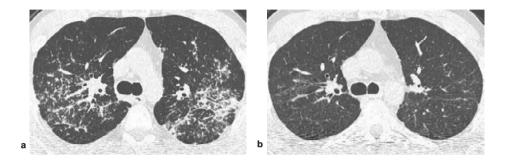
High-resolution computed tomography (HRCT) studies from a 36-year-old man with a history of 5 years of biopsy-proven sarcoidosis. Because of respiratory functional impairment, he had been previously treated with prednisone, starting at 40 mg daily. This was tapered off because of side-effects to 20 mg daily. No improvement was achieved, so treatment with methotrexate (MTX) was started. a. HRCT before treatment with MTX, showing multiple intraparenchymal nodules, focal pleural thickening, septal and nonseptal lines, and thickening or irregularity of the bronchovascular bundle. De h. HRCT after 6 months of treatment with 12.5 mg MTX weekly and 5 mg folic acid once a week orally, together with 10 mg prednisone daily, showing substantial improvement.
